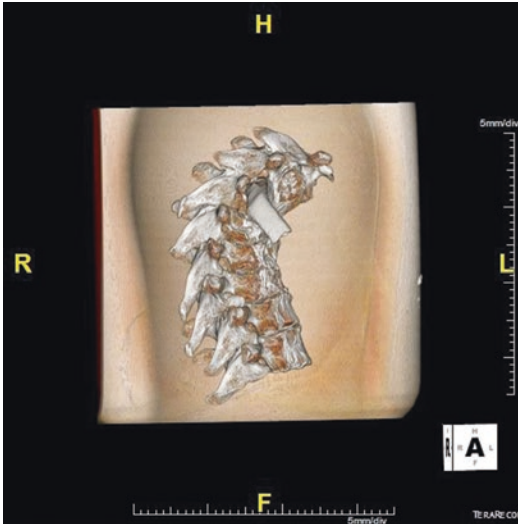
CT of the spine affected by Pott's disease, from Azzio (Northern Italy) archaeological site
